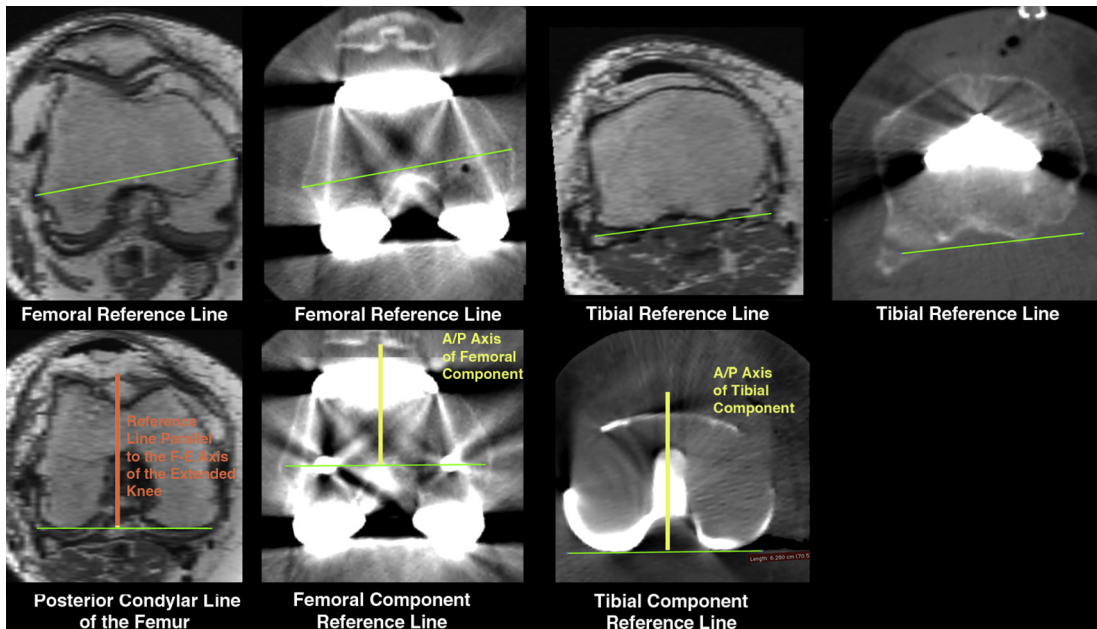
Matched axial views of the femur and tibia on the preoperative MRI and postoperative CT scans. The femoral reference line connects the femoral epicondyles. The tibial reference line connects the posterior tibial condyles. The reference line perpendicular to the posterior condylar line of the femur on the MRI is parallel to the F-E plane of the extended knee. The A-P axis of the femoral component is perpendicular to the femoral component reference line. The A-P axis of the tibial component is perpendicular to the tibial component reference line.
